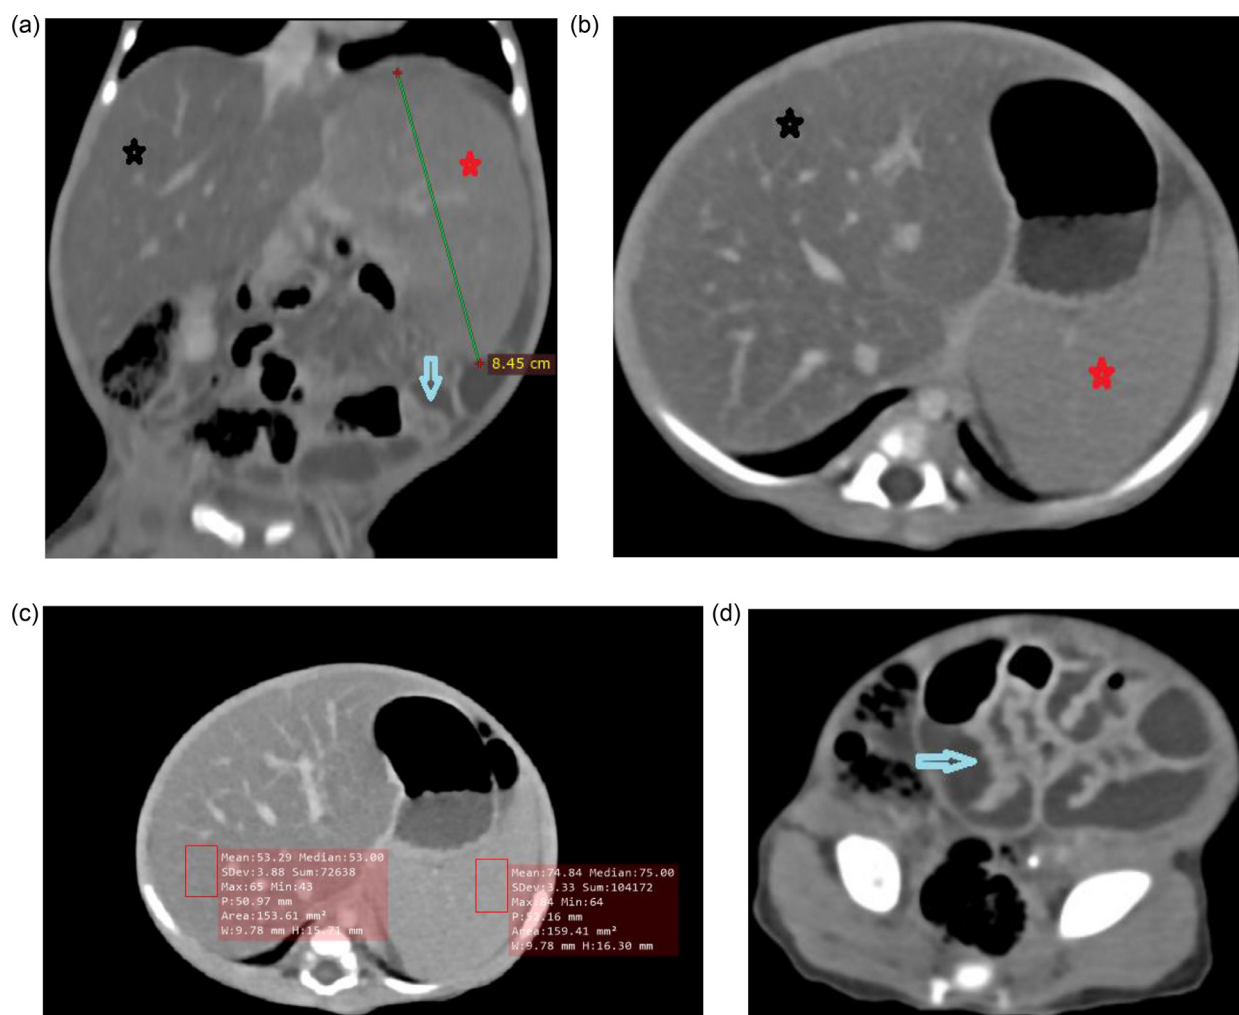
Selected axial and coronal contrast-enhanced abdomen CT scan images demonstrating fatty liver (black asterisk), splenomegaly (red asterisk), hyperenhancing thickened small bowel loops (blue arrows), and perisplenic ascites. Selected axial contrast-enhanced abdomen CT scan demonstrating the Hounsfield units of liver and spleen. (Color version of figure is available online.)
